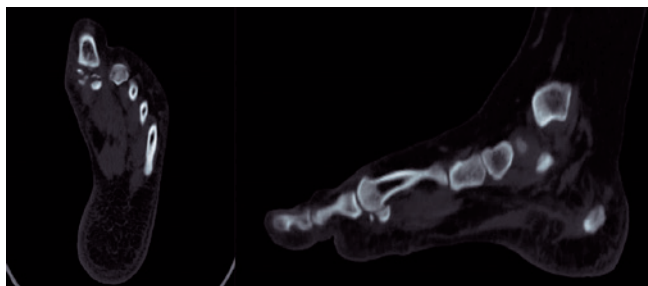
Computed tomography on 10/22/2021.
